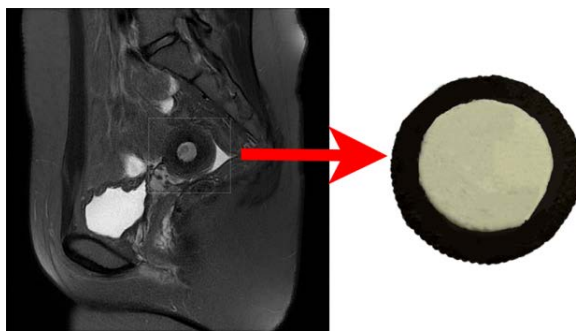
Ultrasonographic, MRI, and pathologic images of an accessory cavitated uterine malformation (ACUM).
